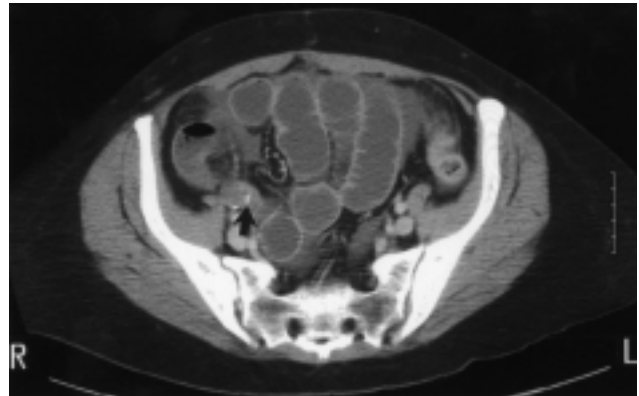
Computed tomogram of the abdomen. Transition point (arrow).
